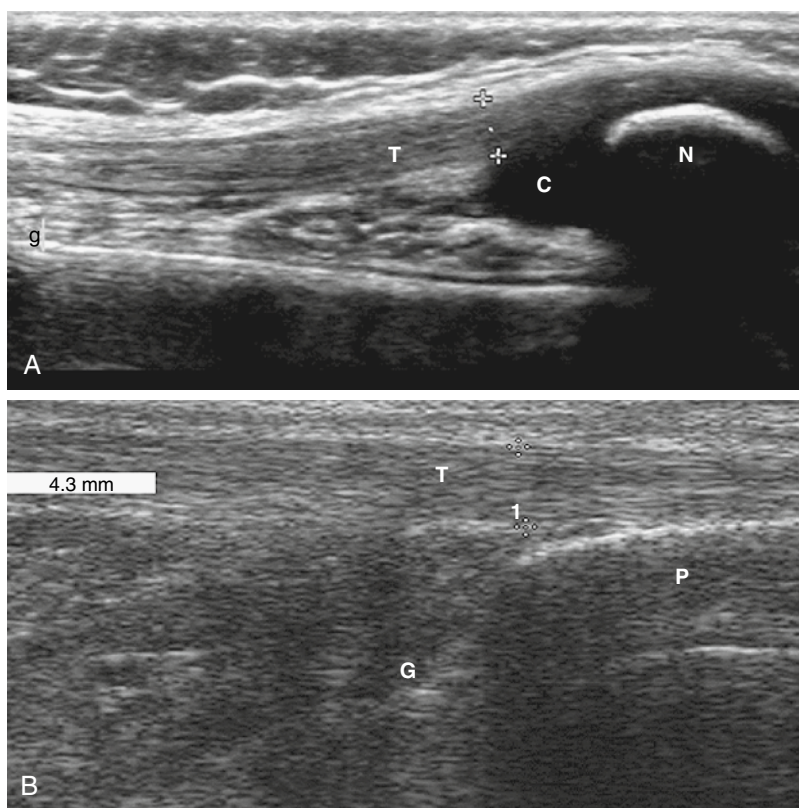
3 A, Ultrasound shows a normal extensor tendon in a 3-year, 2-month-old girl. The sonogram shows the distal portion of the tendon (*cross*) with well-defined echogenic margins. C, patellar cartilage; N, ossification center; T, extensor tendon. B, Complete ossification of the patella is seen in a 15-year, 2-month-old boy. G, fat; P, patella; T, quadriceps tendon.
